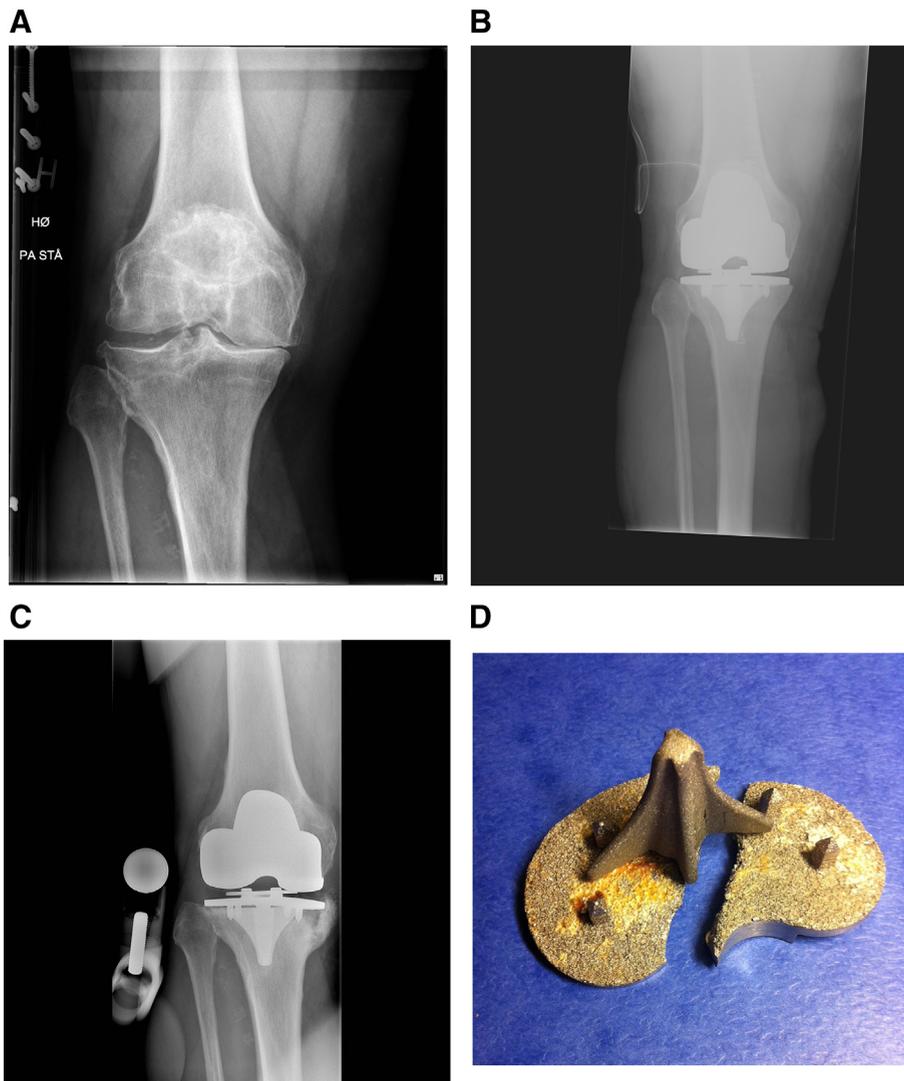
Case 1: Antero-posterior radiograph of the right knee. (A) preoperative, (B) postoperative, (C) 10 months after primary surgery, and (D) picture of retrieved tibia component with fracture of the metallic baseplate.
